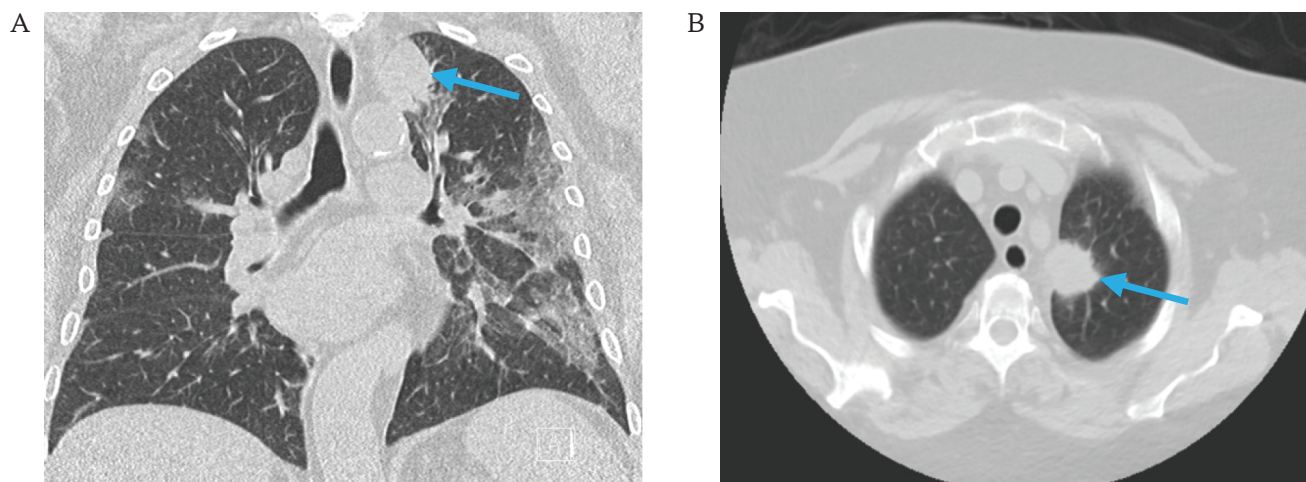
Chest computed tomography at the time of initial evaluation (7th of August 2021).
